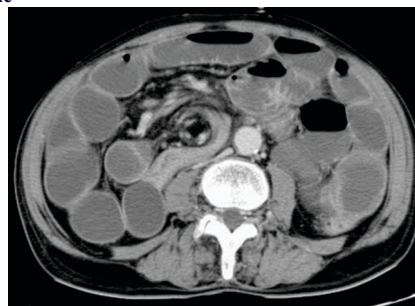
CT axial section showing "whirlpool" sign
